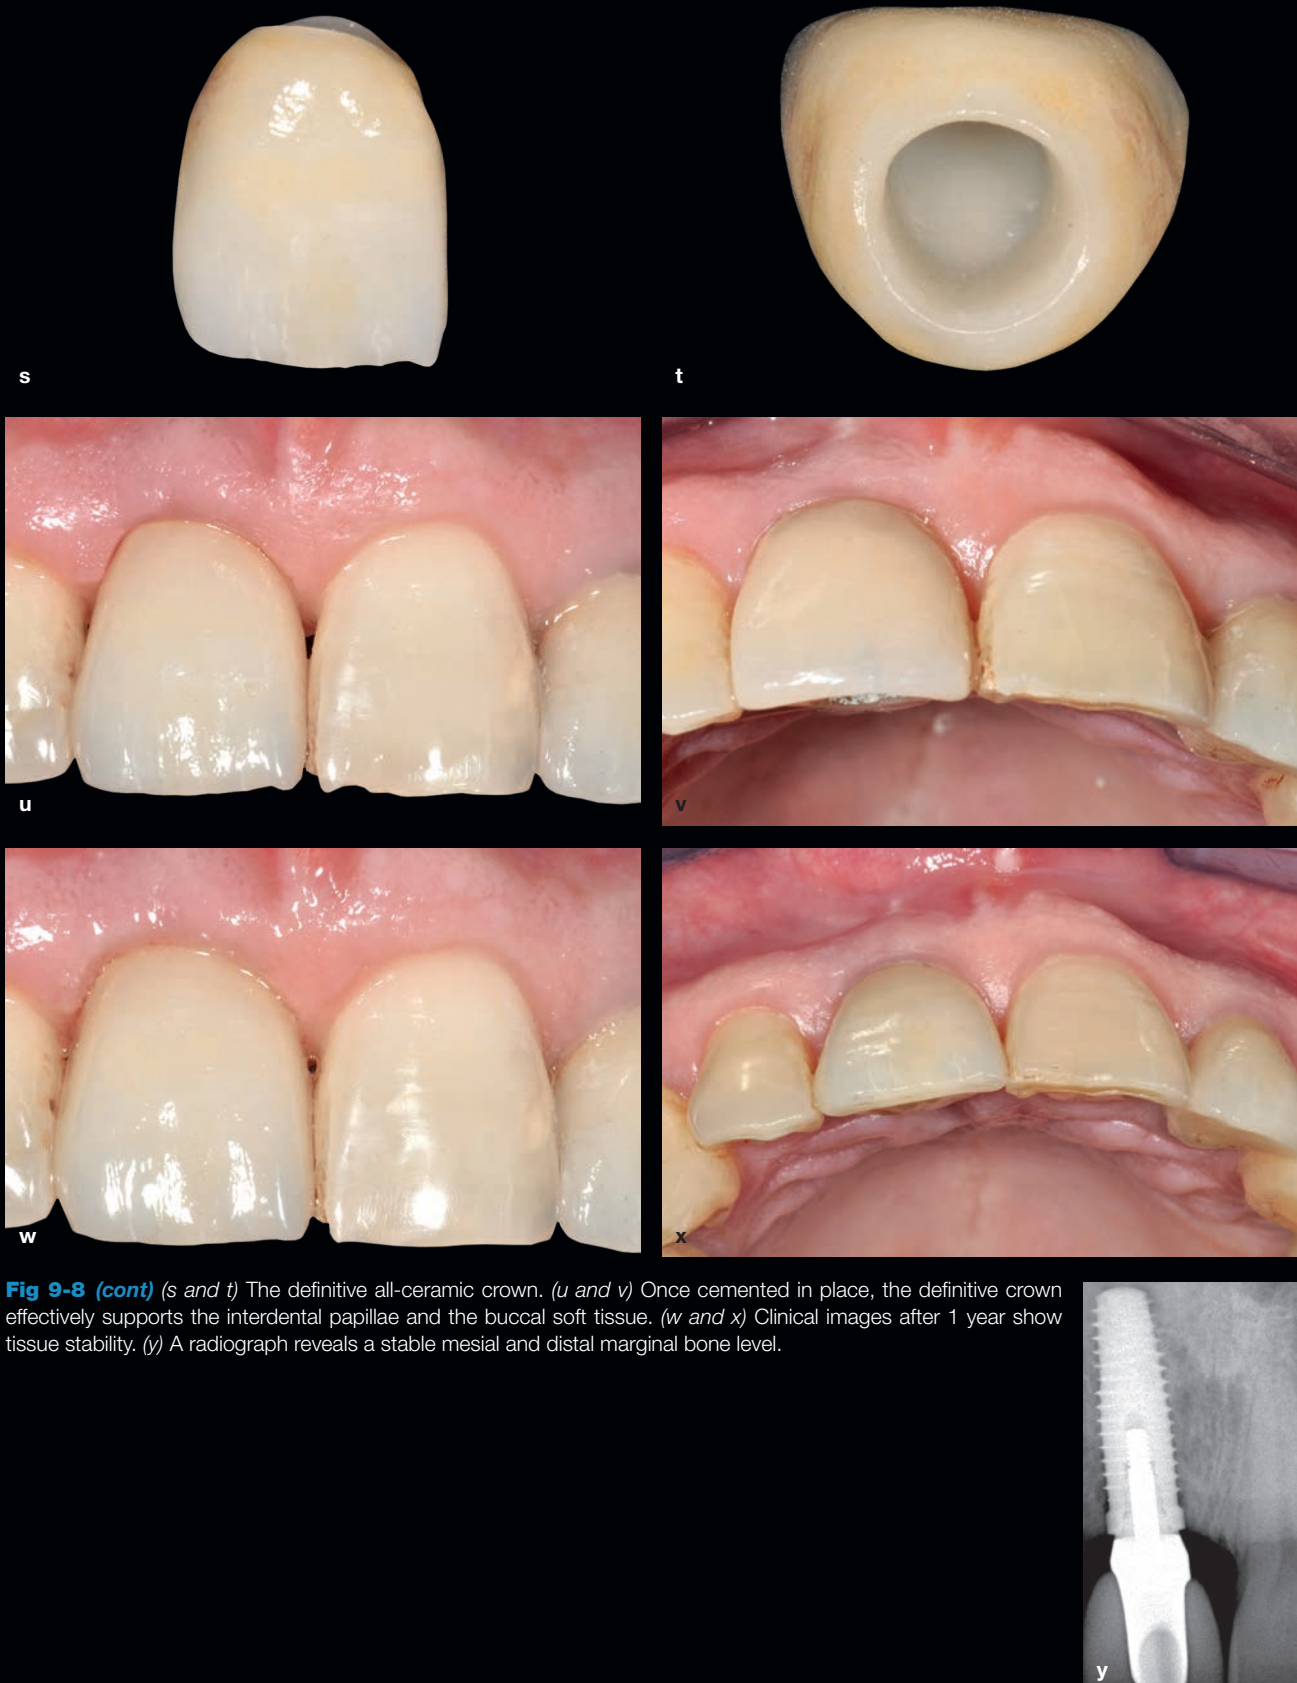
(cont) (s and t) The definitive all-ceramic crown. (u and v) Once cemented in place, the definitive crown effectively supports the interdental papillae and the buccal soft tissue. (w and x) Clinical images after 1 year show tissue stability. (y) A radiograph reveals a stable mesial and distal marginal bone level.
